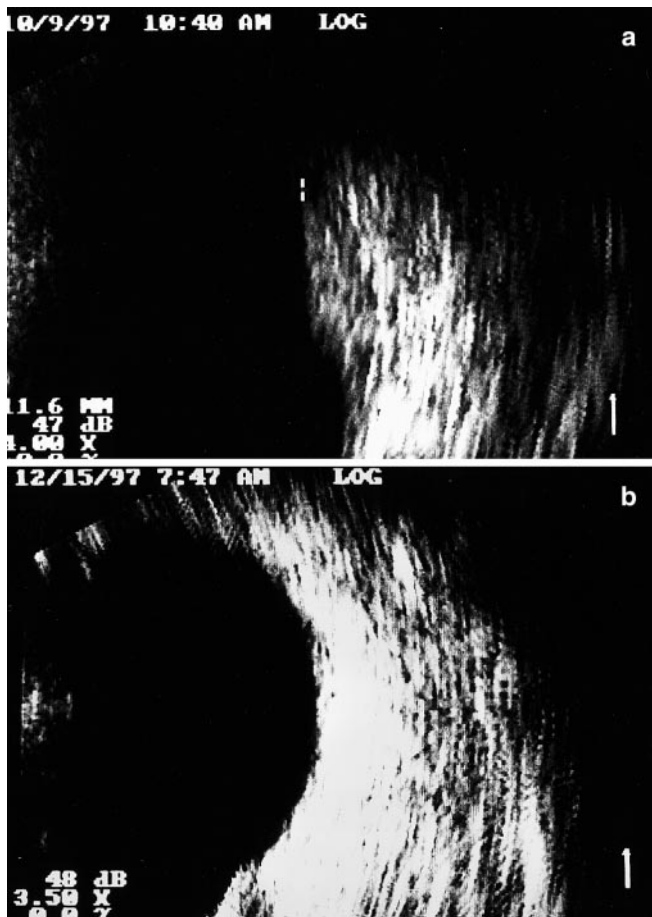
Ultrasound documenting a tumor height before therapy and b tumor regression 2 months after treatment
